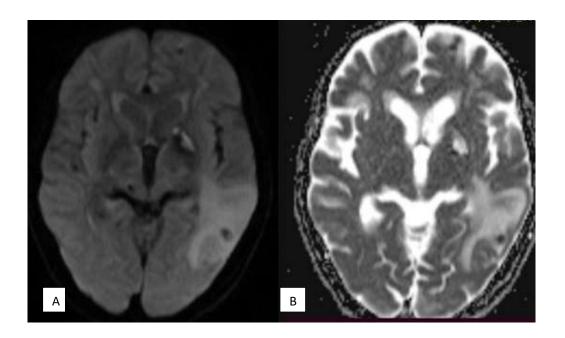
Diffusion weighted imaging features in a case of Neurocysticercosis MRI Brain Axial sections A) Axial DWI (B) Axial ADC map – No restriction of diffusion.
